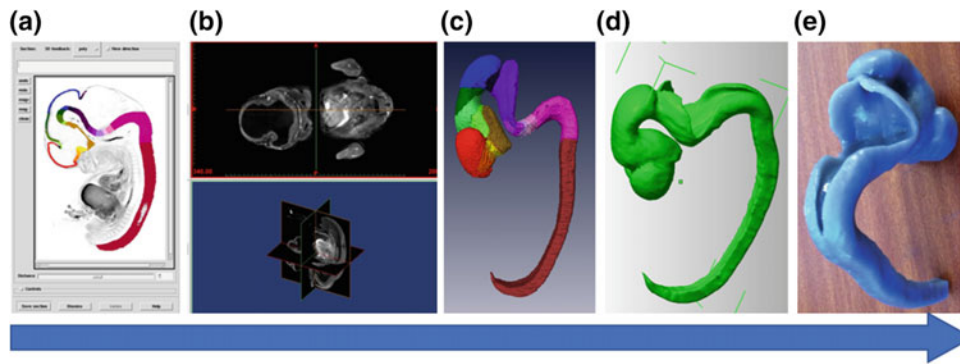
Embryonic model conversion: From a organ ‘Coloring’ to b MRI, c BioCAD, d Slicing, e 3D Printing. Institute of Genetic Medicine (Dr. Susan Lindsay)
